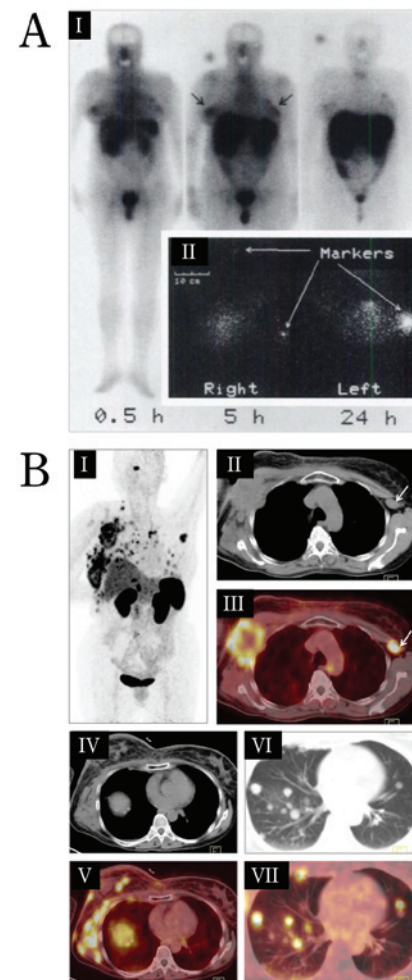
Comparison of a planar whole body scintigram (A) and a PET/CT scan (B). The improvements within nuclear medicine enable SSTR-mediated tumor visualization with a higher sensitivity and resolution, leading to improved diagnostic accuracy. A) Whole-body scintigram of a patient with confirmed bilateral ductal carcinoma (Bajc et al. (18)). Images were obtained 0.5, 5 and 24 h after i.v. injection of 110 MBq ^{111}In -DTPA-octreotide (18). B) ^{68}Ga -DOTA-NOC PET/CT scan of a patient with a NET of the breast (Mukherjee et al. (37)). SSTR-expressing metastatic lesions were found in multiple bilateral axillary and right cervical lymph nodes, bilateral lungs and multiple skeletal sites (I-VII) (37).
